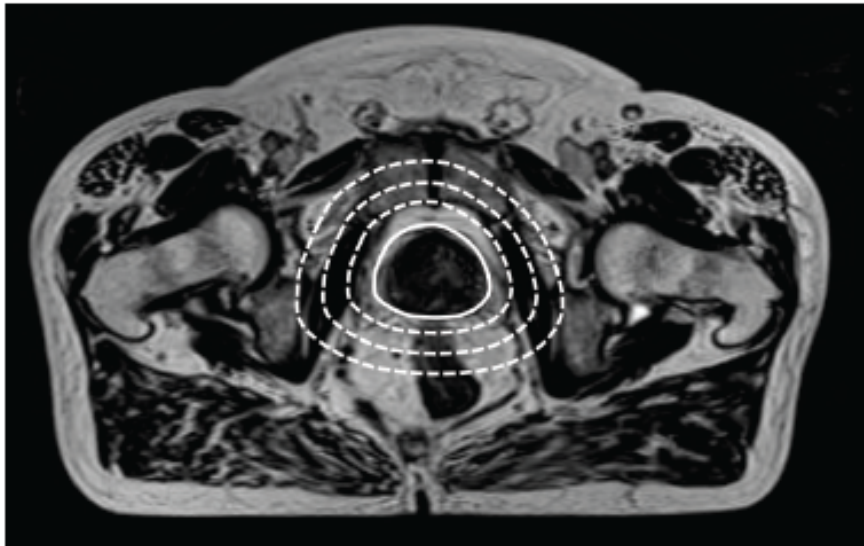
Registration volumes. The figure demonstrates an MR image with the different registration volumes RV_0 (solid line), RV_1 , RV_2 and RV_3 (dotted lines).
